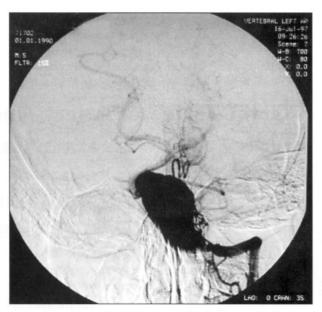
Left: An axial T1-weighted image shows a giant, partially thrombosed aneurysm of the left vertebral artery compressing the brainstem. Right: A selective angiogram of the left vertebral artery reveals a giant fusiform aneurysm.
